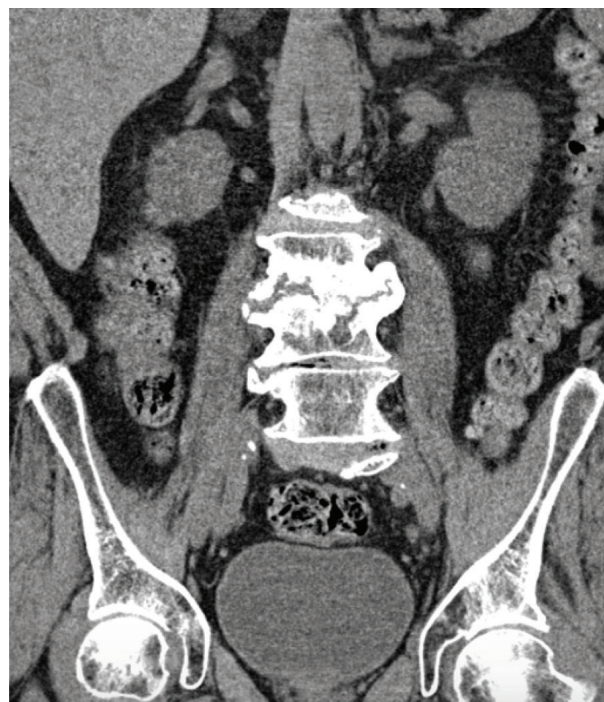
CT showing involvement of the right psoas muscle. CT, computed tomography.
